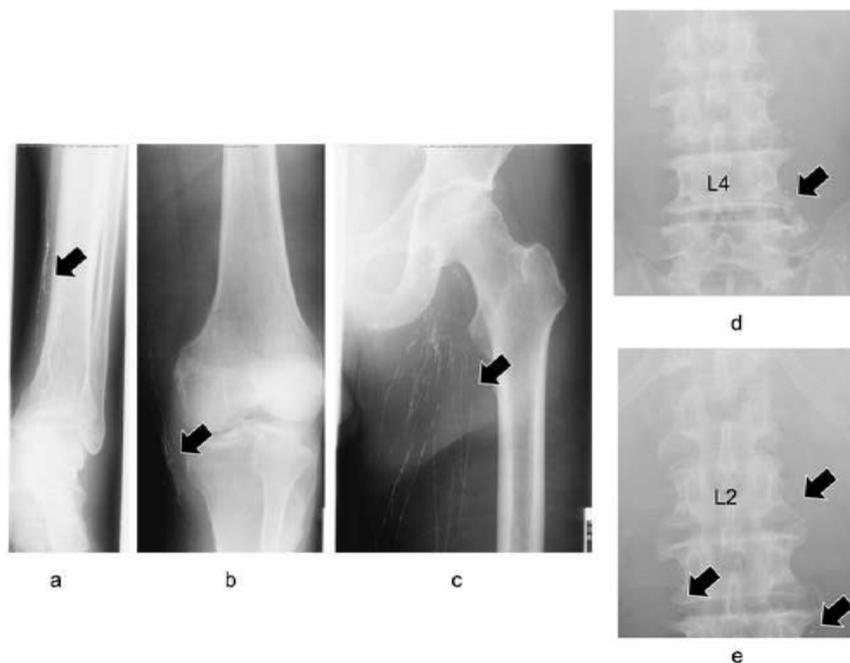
Radiography of lipiodol lymphangiography, black arrows, enhanced lymphatic ducts; (a) calf; (b) knee; (c) groin; (d) L4; (e) L2.
